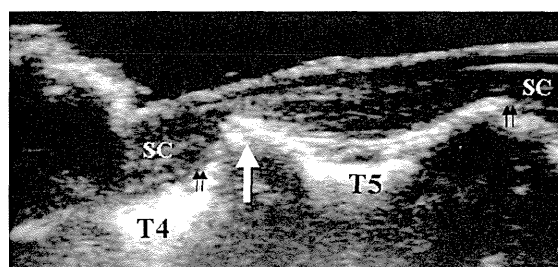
Intraoperative spinal ultrasonography in the midsagittal plane after laminectomy showing anterior impingement of the spinal cord (SC) by the beak-type ossification of the posterior longitudinal ligament at T4/5 (arrow) and the absence of the subarachnoid space on the ventral side of the spinal cord from T4/5 to T5/6 (double arrows).
